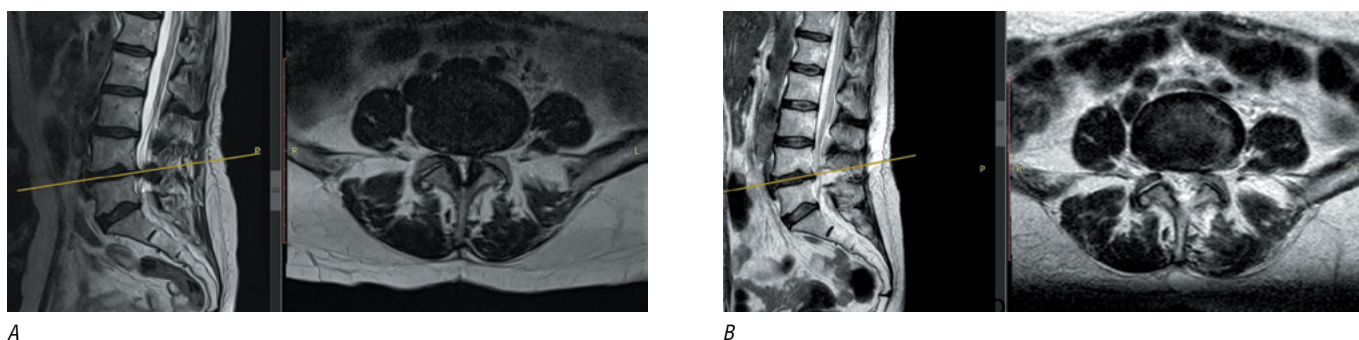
MRI of a patient with central degenerative stenosis at L4–L5 level. A, before surgery; B, after endoscopic decompression with DeltaJoimax.
